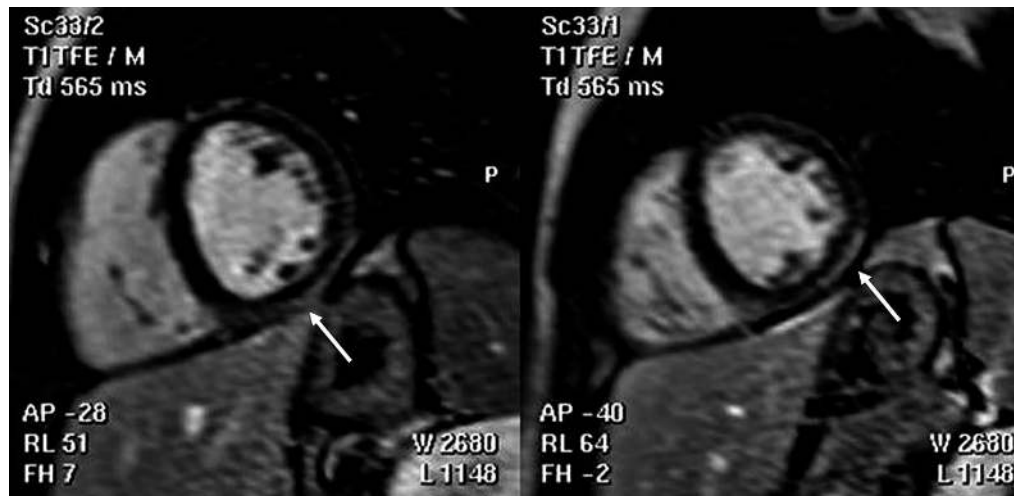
Delayed enhancement-cardiac magnetic resonance images of 2 contiguous mid short-axis views of the left ventricle in a patient with acute myocarditis. White arrows indicate the myocardial damage (hyperenhancement areas) involving the subepicardial layers of the inferior and inferolateral walls.
